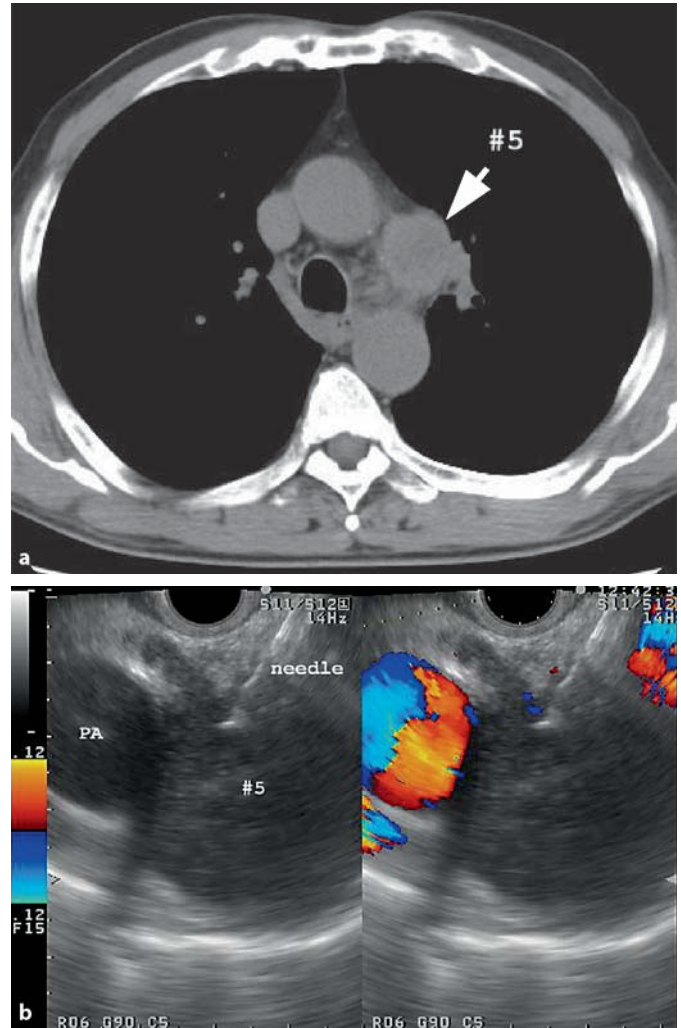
A case of NSCLC with lymph node swelling at level 5. a The CT image shows an enlarged lymph node at level 5 (arrow). b EUS-FNA was performed on the lymph node. PA = Right pulmonary artery.
